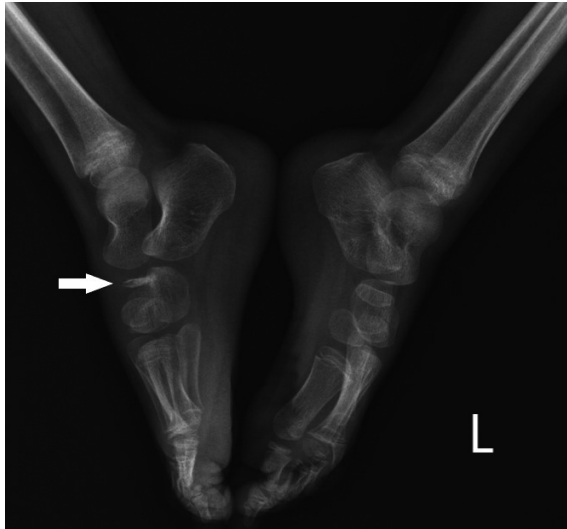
X-ray image of the flattened, fragmented and sclerotic navicular bone (white arrow)
